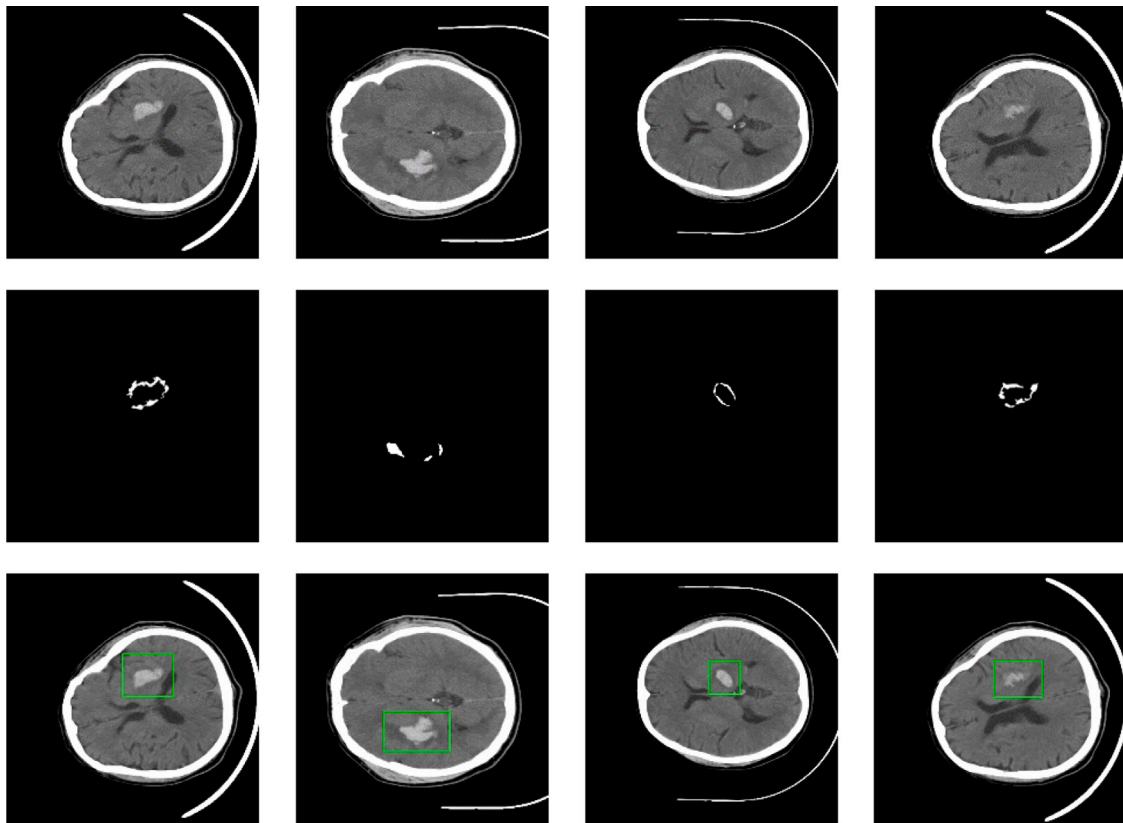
The labels of SICH-CT-IDS. The first row represents the original CT images, the second row represents the segmentation labels, and the third row represents the detection labels.
